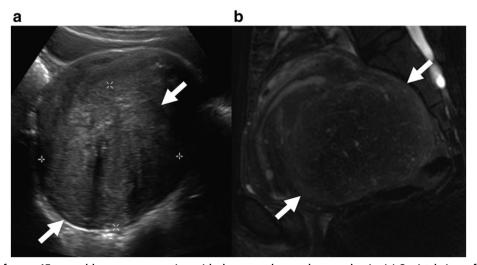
Images from a 45-year-old woman presenting with dysmenorrhea and menorrhagia. (a) Sagittal view of the uterus from a pelvic US demonstrating a large posterior uterine body mass diagnosed as a leiomyoma (white arrows). (b) Sagittal T<sub>2</sub>-weighted single-shot fast spin echo image from a pelvic MRI performed 25 days after the US revealing a T<sub>2</sub> hypointense posterior uterine body mass that contained numerous small T<sub>2</sub> hyperintense cysts and was separate from the junctional zone, consistent with an adenomyoma (white arrows). The clinical presentation was more consistent with adenomyosis rather than an intramural fibroid.
